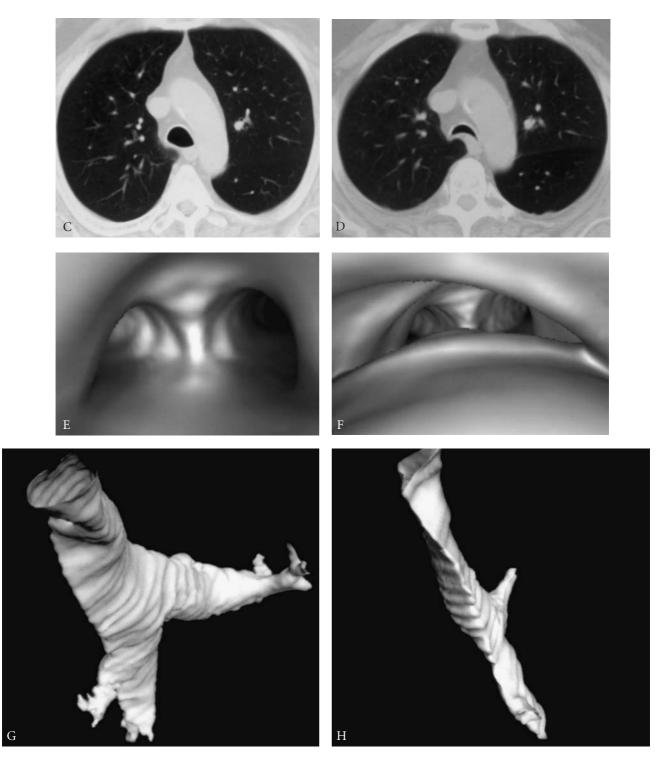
(CONTINUED) C, Inspiratory–expiratory computed tomography (CT) scans demonstrate the degree of narrowing of the affected intrathoracic trachea. Inspiratory view. D, Expiration at the same level. E, Virtual bronchoscopy from a CT scan, showing the supracarinal trachea in inspiration in the same patient. F, View at the same level in expiration. G, Three-dimensional CT reconstructions of the trachea and main bronchi in another patient, a 57-year-old man with severely symptomatic obstructive malacia. Anterior view. Note the transition from a circular cervical configuration through a triangular shape to flattened cartilages distally. H, Oblique view showing ridging of the membranous wall. Corresponding bronchoscopic views are seen in Figures 15-4C and 15-4D.
